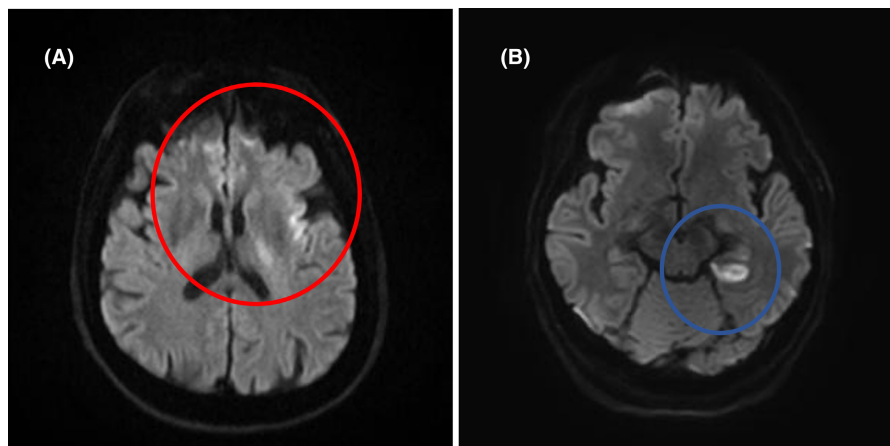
Magnetic resonance imaging showing ischemic stroke (red circle and blue circle) (A: father; B: son).
